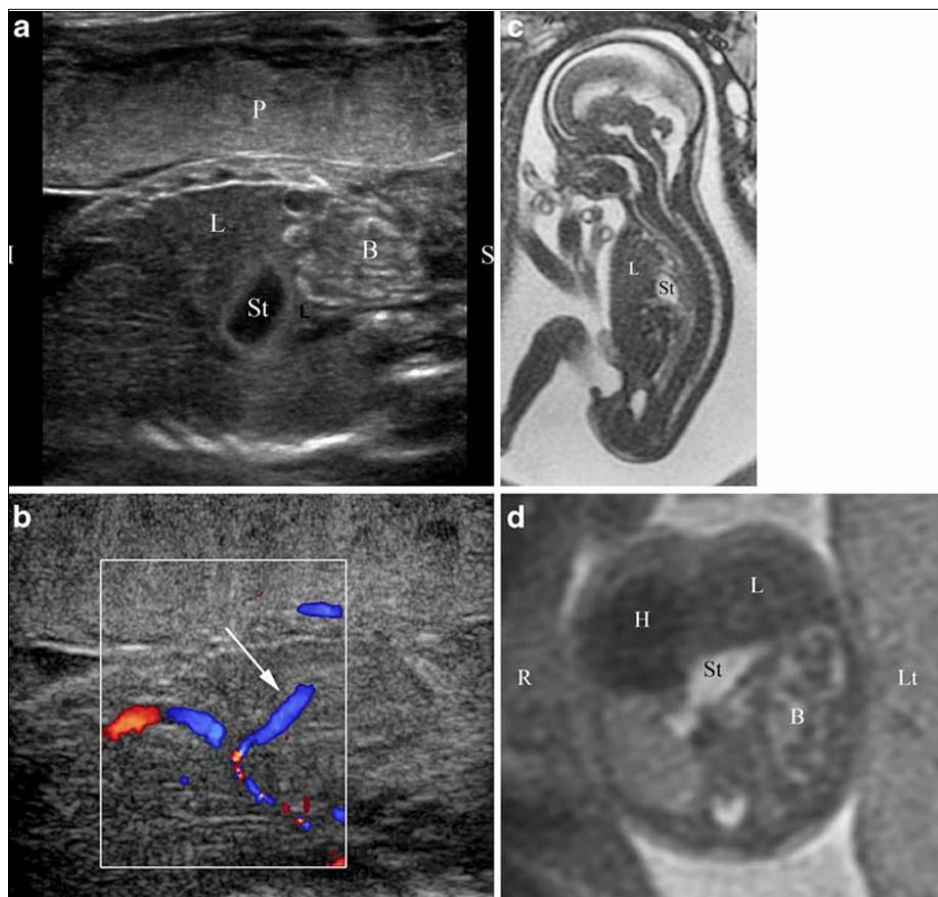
Left Bochdalek hernia in a 20-week fetus. a Sagittal sonogram of the left fetal chest shows herniation of echogenic bowel (B), stomach (St) and liver (L) into the fetal chest (P placenta). b Color Doppler sonogram shows superior displacement of hepatic vessels (arrow) into the fetal chest. c, d Sagittal (c) and axial (d) FIESTA and T2-W MRI images of the fetus obtained on the same day show intrathoracic herniation of the liver (L), bowel (B) and stomach (St) with displacement of the heart (H) to the right side (R right, Lt left)
